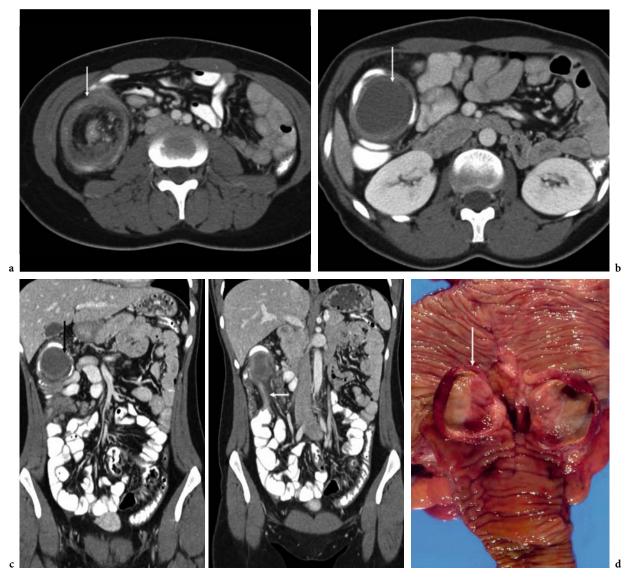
Use of coronal reformatted images to assist in diagnosis. a Axial CT image shows large intussusception in the right lower quadrant (arrow). b Axial CT slice obtained cephalad to a shows well circumscribed low attenuated mass as lead point (arrow). c Coronal reformatted image (left) show that the mass is spherical (arrow) and at the level of the ileo-cecal valve (right). Note terminal ileum (arrow). The spherical nature of the lesion excluded mucocele and therefore the most likely diagnosis is duplication cyst. d Duplication cyst was confirmed at surgery (arrow)
